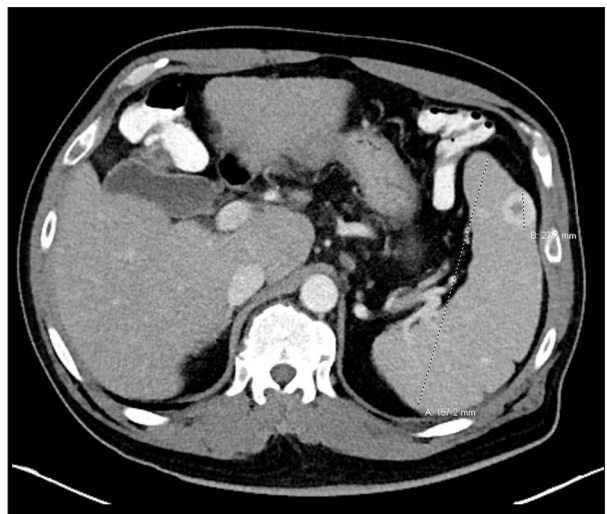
CT Abdomen and pelvis demonstrating cirrhotic morphology of the liver, splenomegaly, and splenic lesions.
